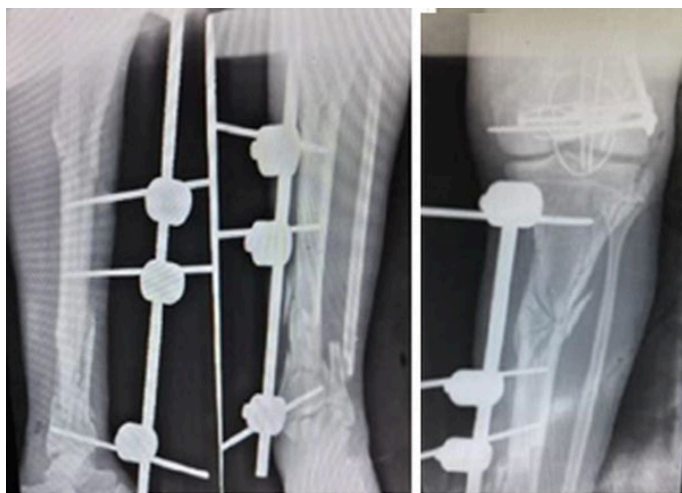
(A,B) showing immediate post external fixation, uniplanar fixator applied for tibial fracture seen in above radiograph.(C,D) intraoperative pictures showing distal femur plating and patellar TBW with encirclage.
